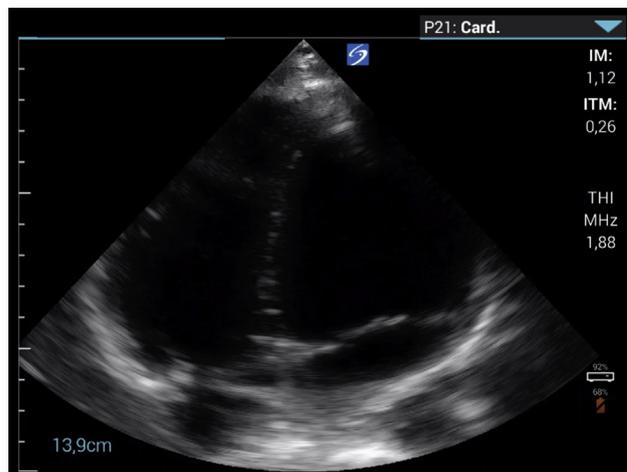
Apical 4-chamber view on the morning of Day 8.
